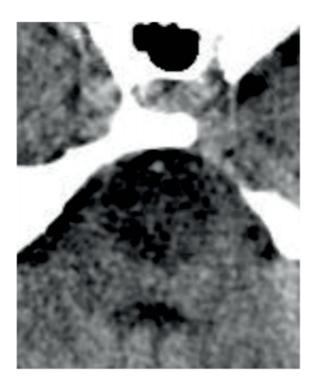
CT Skull without contrast. Spontaneous hyperdensity of a. basic.
